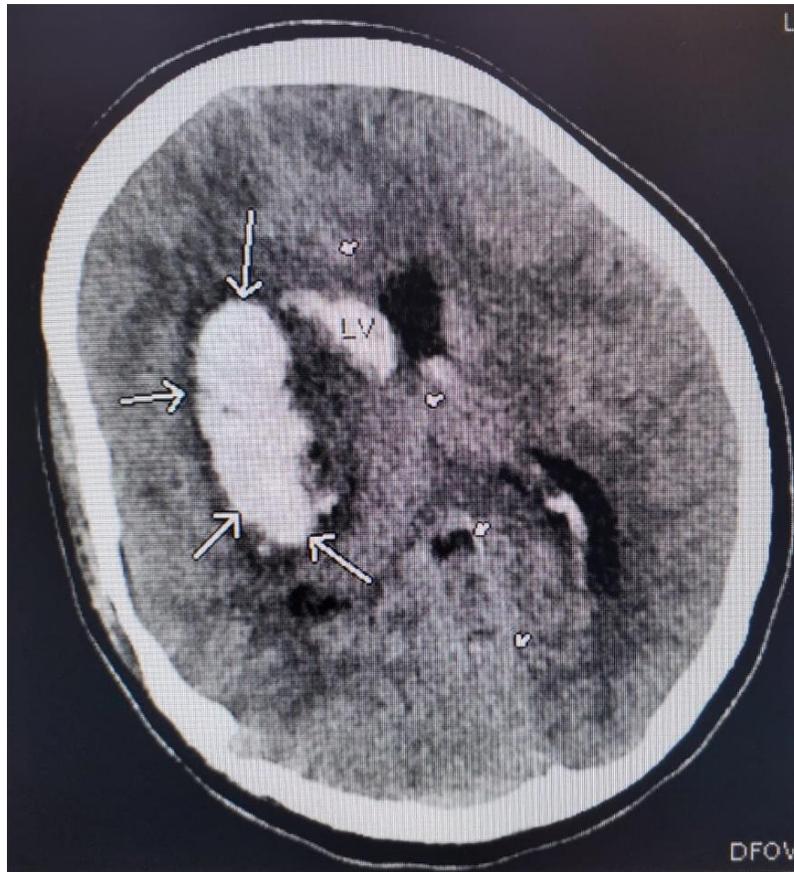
Image of an axial view of a computed tomographic scan of the head.
